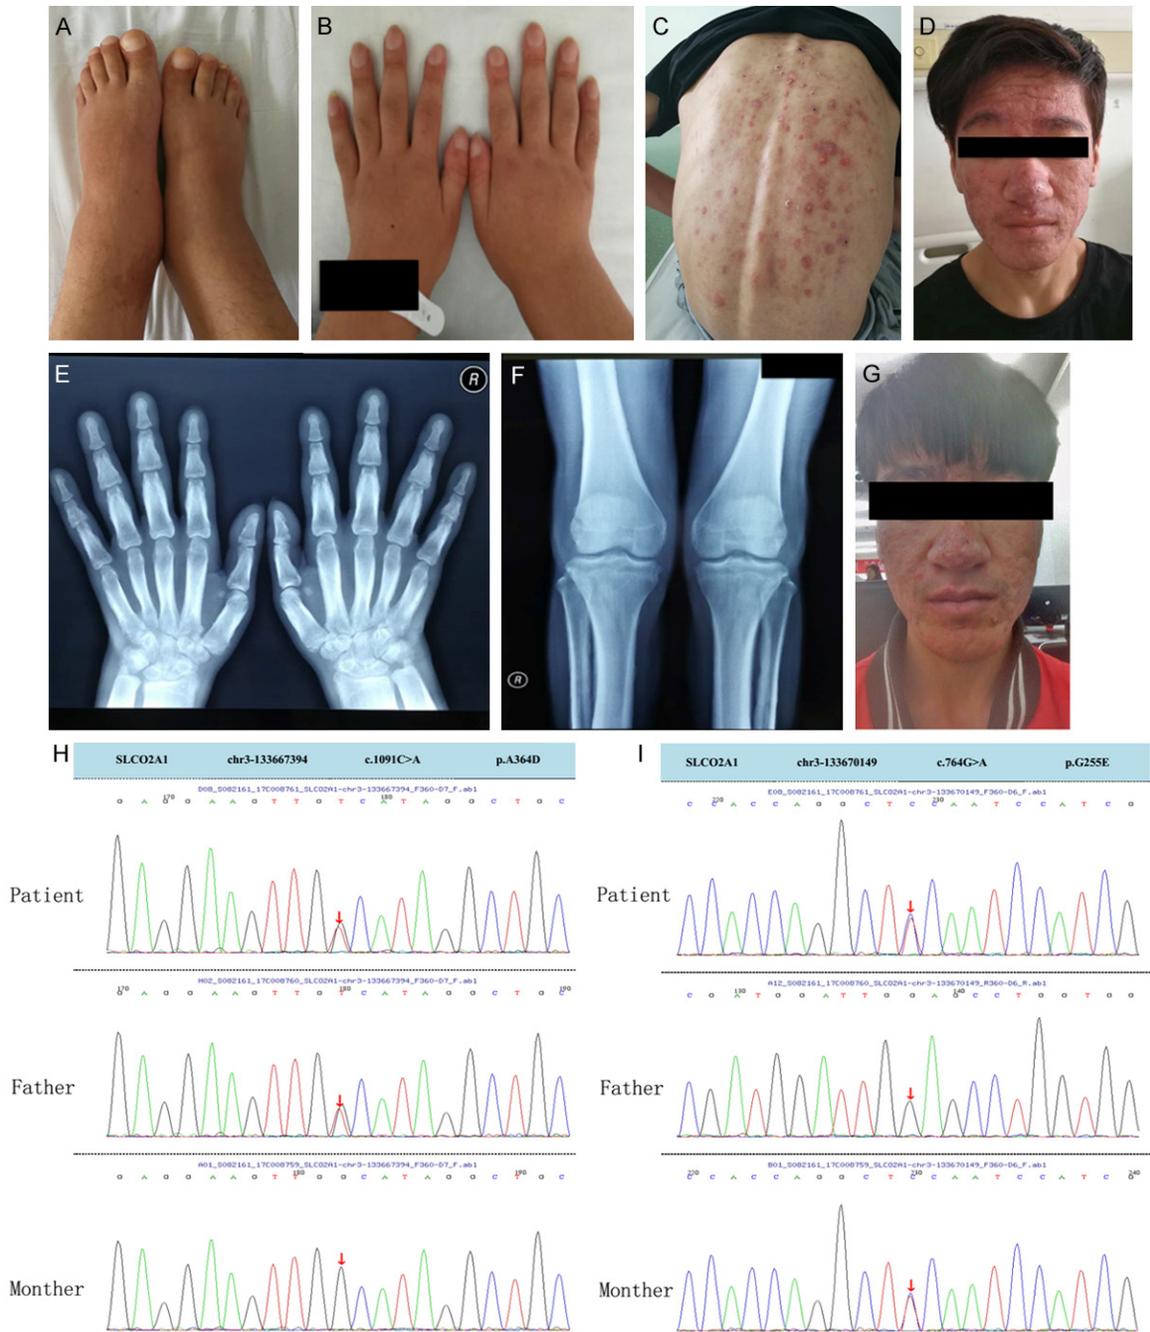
Physical examination, X-rays, and genetic examination results of the patient. A. Digital clubbing of feet. B. Digital clubbing of hands. C. Back skin hyperplasia and acne. D. Hyperplasia and acne in face. E. X-ray showing periostosis in bilateral wrists. F. X-ray showing periostosis in bilateral femur, tibia and fibula, and an increase in soft tissue content. G. The skin change was relieved after the patient was put on celecoxib for one year. H and I. The genetic examinations of the patient and his parents showing two compound heterozygous missense mutations in *SLCO2A1*.
